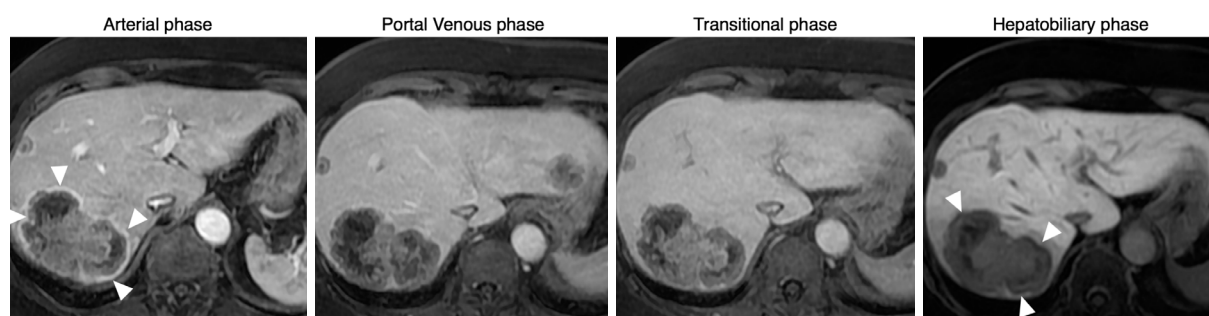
Gadoxetate enhanced MRI: 55 year-old male with chronic hepatitis B infection. A targetoid observation (65 mm) exhibits features of LR-M: rim arterial phase hyperenhancement and peripheral washout (arrowheads). After biopsy, the lesion was diagnosed as liver metastasis from colorectal cancer
